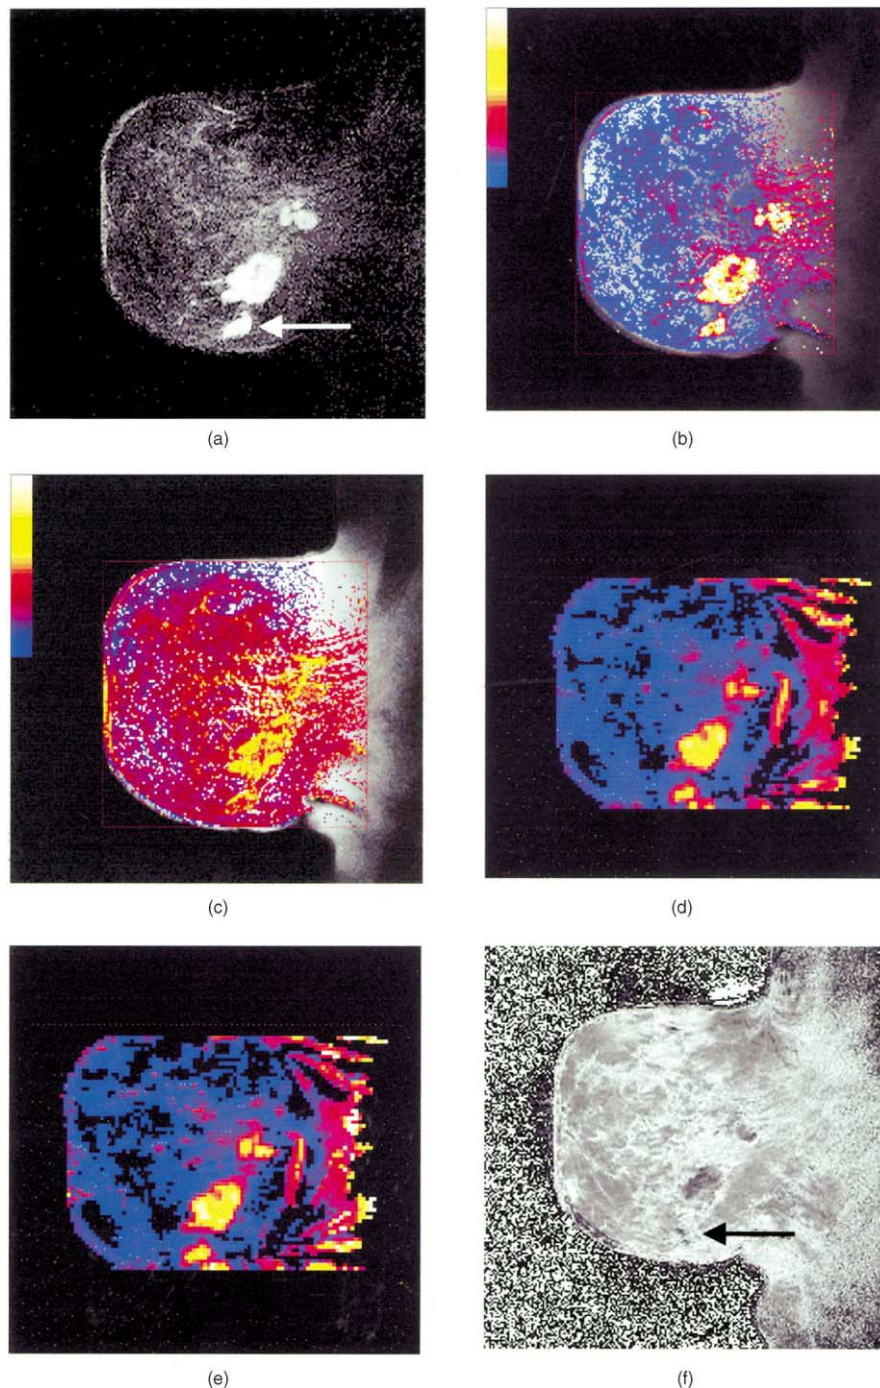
Multifunctional MRI assessment of breast carcinoma. The following series of images were obtained from a 49-year-old woman with multifocal, invasive ductal breast cancer. All images were obtained in a time period acceptable to most patients (50 min). (a) Anatomical, sagittal post contrast enhanced, subtraction MR image of the breast shows multiple foci of irregular enhancement compatible with multifocal breast cancer. The arrow refers to a feature indicated in (f) below. Images (b) and (c) are obtained from a T1-weighted acquisition using 0.1 mmol/kg of contrast medium (Gadopentatate dimeglumine). (b) Transfer constant pixel map shows the permeability surface area product of the vasculature displayed as a pixel map on the anatomical image (maximum transfer constant displayed is 1.0 ml/ml/min). High transfer constant values compared with normal breast and heterogeneous distribution is typical of cancer. (c) Leakage space pixel map at the same slice position (maximum leakage space displayed 100%). Images (d) and (e) are obtained from a T2*-weighted acquisition using 0.2 mmol/kg of contrast medium. (d) Relative blood volume and (e) relative blood flow pixel maps have been obtained at a slightly lower spatial resolution, but at the same anatomical location. The tumour foci are noted to be markedly hypervascular. Note the good correspondence between perfusion parameters (d, blood volume and e, blood flow) and the permeability parameter maps (b, transfer constant). (f) Synthetic R2* maps calculated from a series of Blood Oxygenation Level Dependent (BOLD) images obtained at the same level. The BOLD images themselves are not shown. Lighter colours indicate poorer tissue oxygenation because of greater levels of deoxyhaemoglobin. The largest lesion is better oxygenated than normal tissues. A disparity between tissue oxygenation (greater deoxyhaemoglobin) and blood flow (high flow) is seen in the lowest lesion on its posterior aspect indicated by the arrows on (a) and (f).
